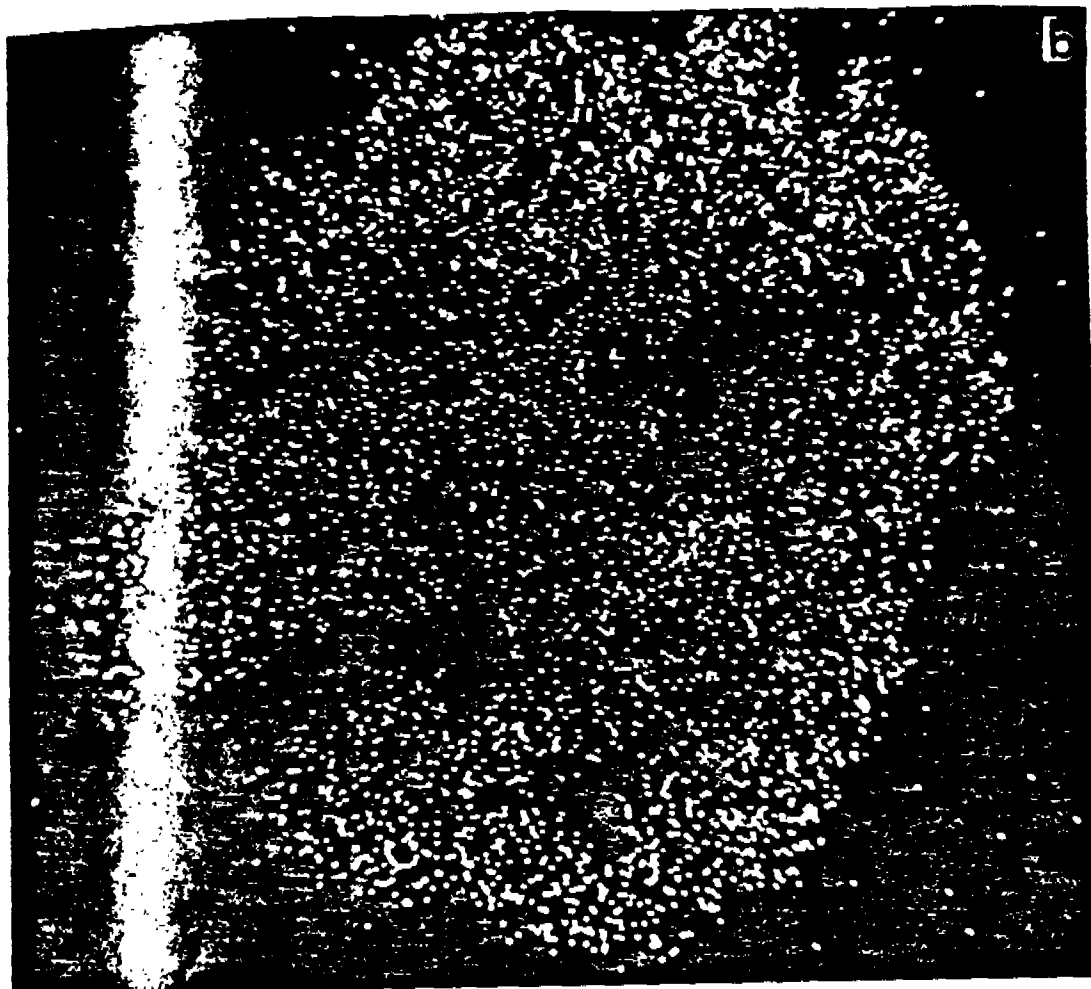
Chlorine x-ray map of the same area and magnification depicted in Fig. 4. The white dots indicate the presence of the element chlorine. Note that the dots are clustered in the same area as the PVC particles, thus confirming the identification of the PVC particles.
